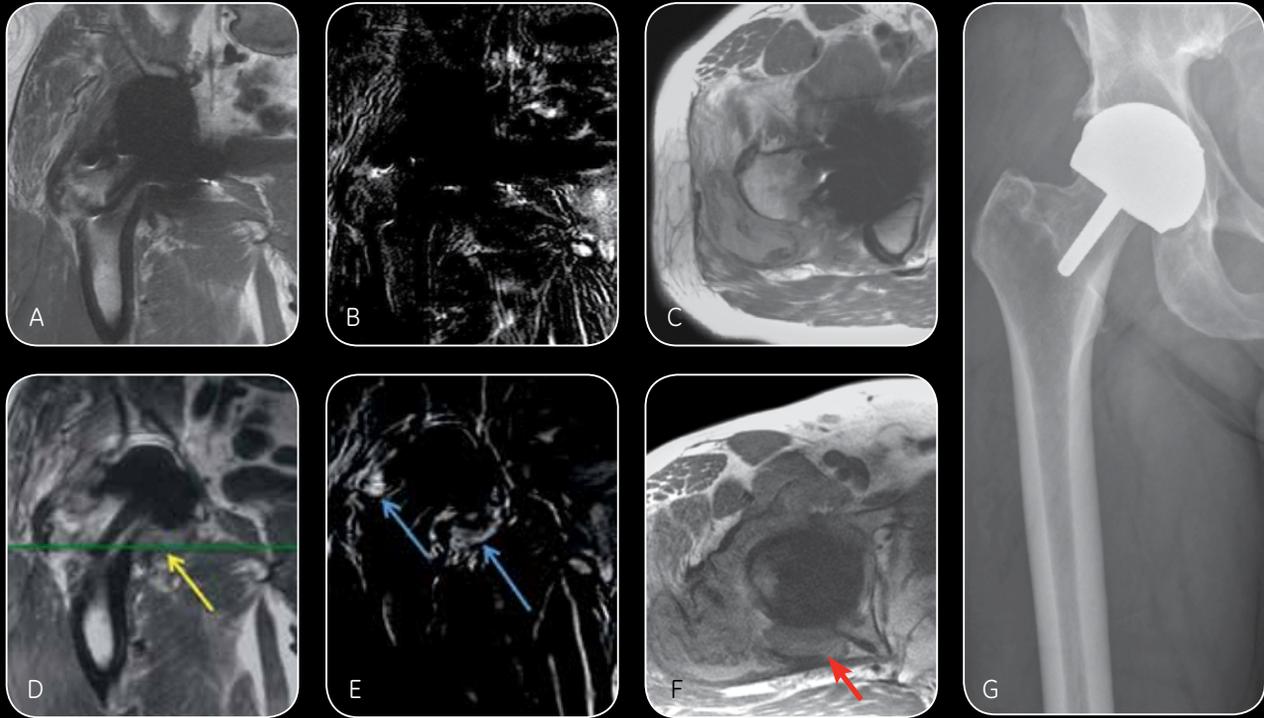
MARS (A-C) and MAVRIC SL (D-F) images of a hip resurfacing implant at 1.5T. The use of MAVRIC SL clearly visualizes regions of adverse local tissue reaction (arrows) in the T1w (D), contrast-subtracted (E), and proton density weighted (F) images. Implant is clearly visualized in the radiograph (G).
